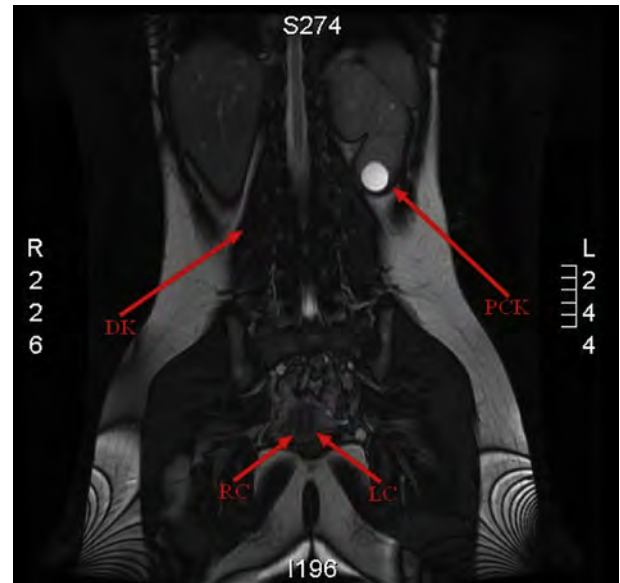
Follow-up of magnetic resonance imaging 1 year later showing double cervixes with absence of a previous right distended mass, right renal dysplasia, and left polycystic kidney. LC = left cervix; RC = right cervix; RDK = right dysplastic kidney; RPCK = right polycystic kidney.
